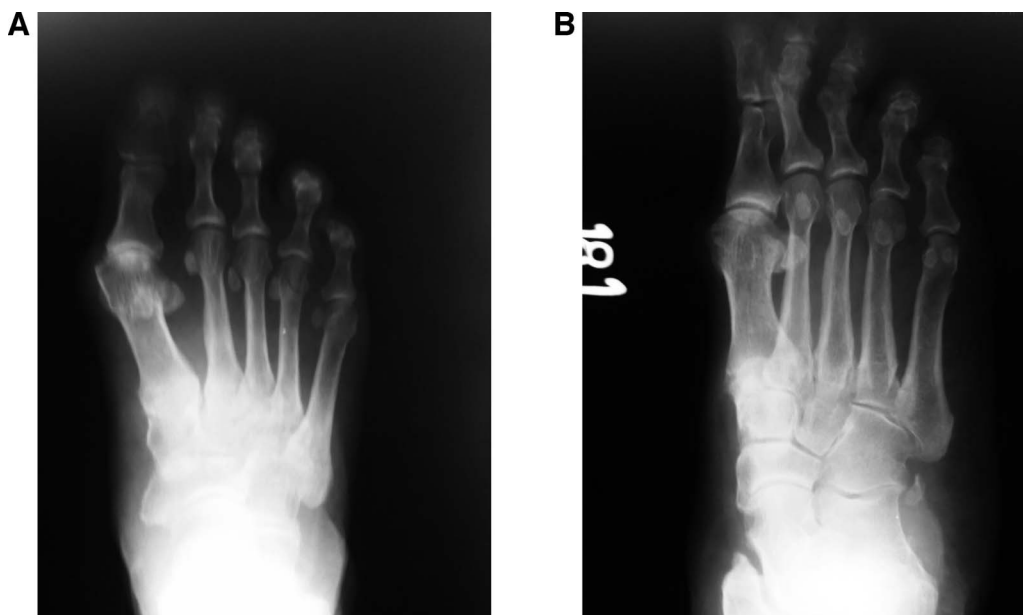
Dorsoplantar (A) and oblique (B) radiographs of the patient.
